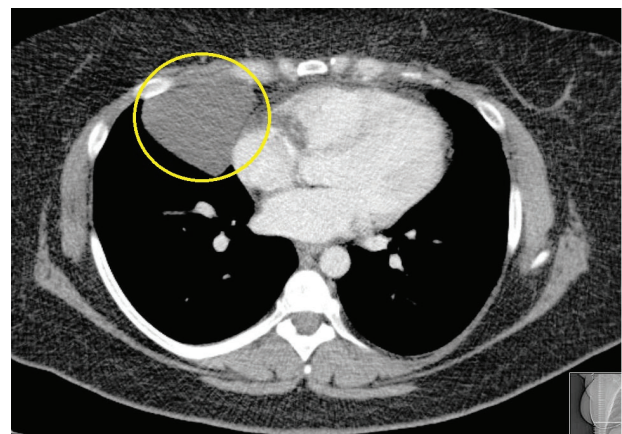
A contrast thoracic CT confirmed the presence of an anterior basal right-sided PPC (inside the yellow circle) sized 5.5 cm craniocaudally, 5 cm anteroposterior and 6 cm laterally without pathologically enlarged lymph nodes and pleural effusion.
